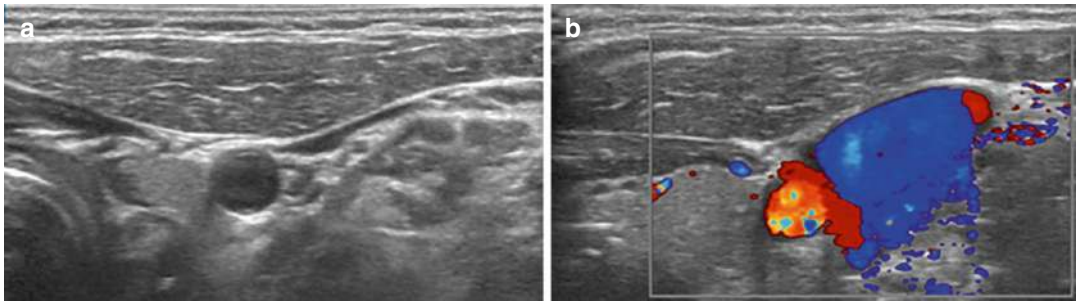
Confirm patency of the vein: (a) compression; (b) colour Doppler
